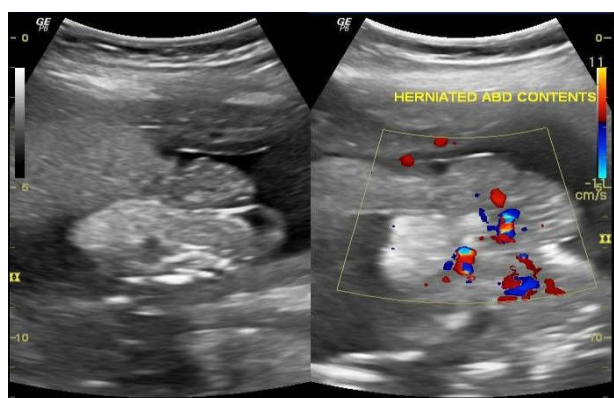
Ultrasound image showing large abdominal wall defect with herniated abdominal content
